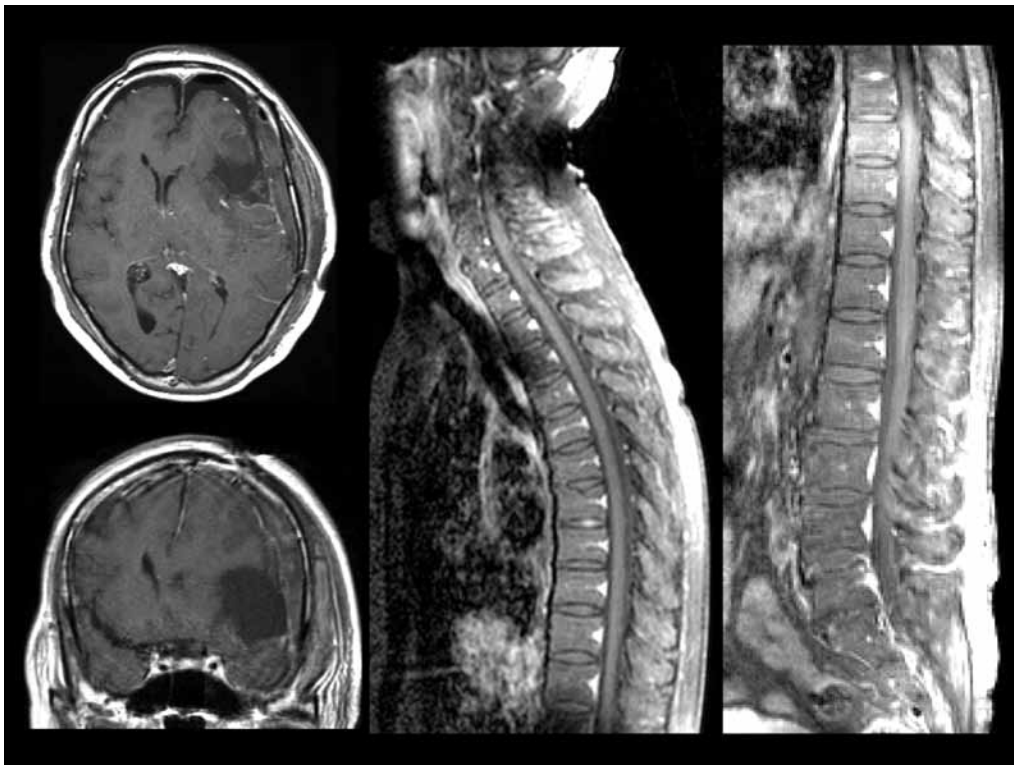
Postoperative magnetic resonance images showed no masses in the brain or spine.
